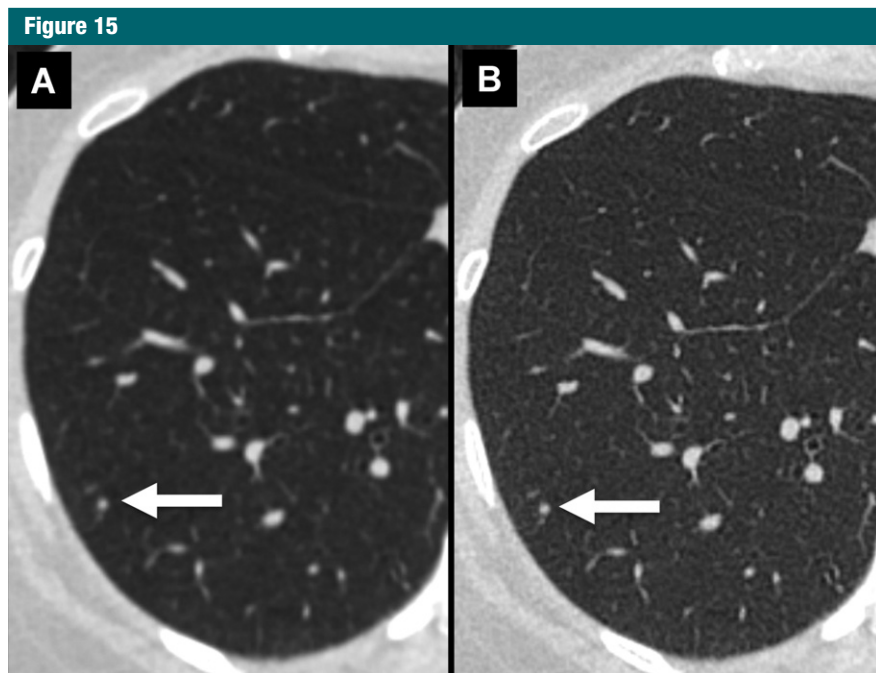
Transverse CT sections through a small nodule in the right lower lobe (same nodule as in 6, *C*) reconstructed, *A*, without and, *B*, with a high-spatial-frequency (sharp) filter. If all other technical parameters are kept equal, image reconstruction with this filter improves visibility of anatomic detail, notably in the pulmonary nodule (arrow).
